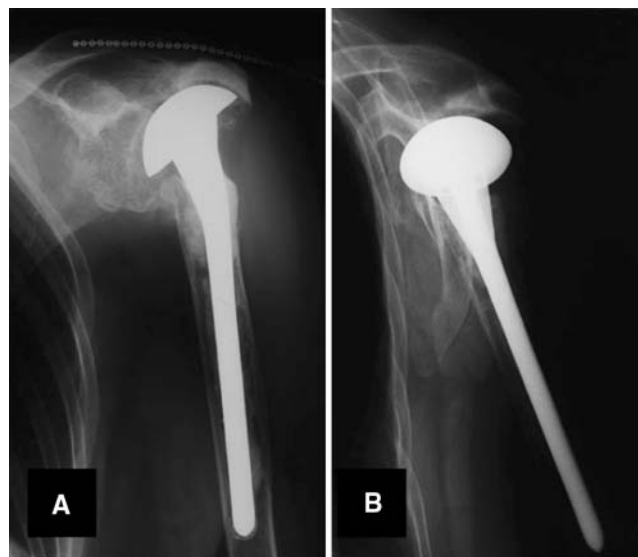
Example of follow-up radiographs (a: anteroposterior view, b: lateral Y-view) demonstrating marked narrowing of subacromial space and absorbed tuberosities.
